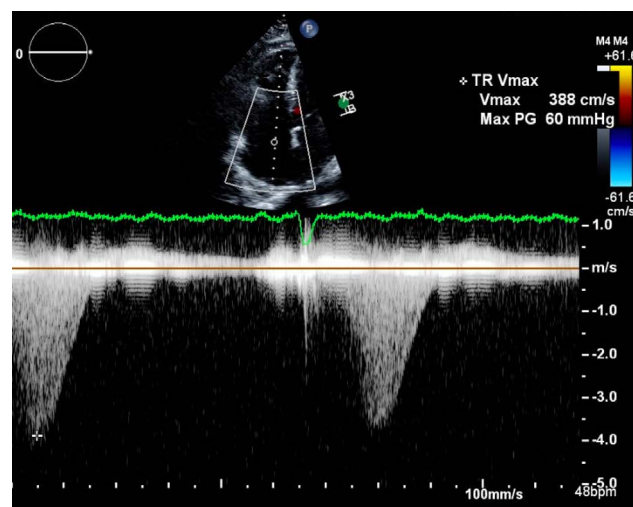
2D Echocardiogram, Continuous wave doppler estimated tricuspid velocity of 3.88m/sec highly suggestive of pulmonary hypertension.
